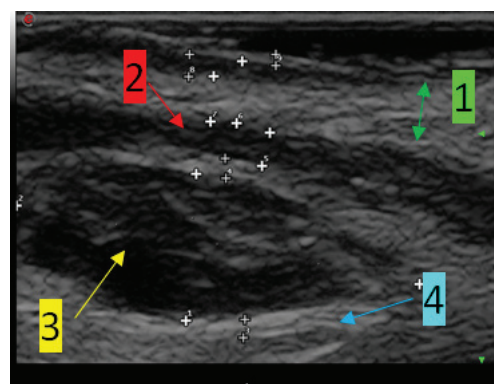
Sonogram, B-mode, periorbital region in the projection of palpebromolar sulcus, horizontal plane at the level of the bone edge of the orbit along the mid-pupil line (arrow 1 – dermis, arrow 2 – m. orbicularis oculi). Hypoechoic, heterogeneous due to hyperechoic thickenings, filler bolus was visualized (arrow 3 - filler). It had clear even contours, was oval shaped, with fibrous capsule (arrow 4 – fibrous capsule) and located under the orbicularis oculi muscle, without signs of perifocal edema. Echo signs of incapsulated filler into periorbital region
